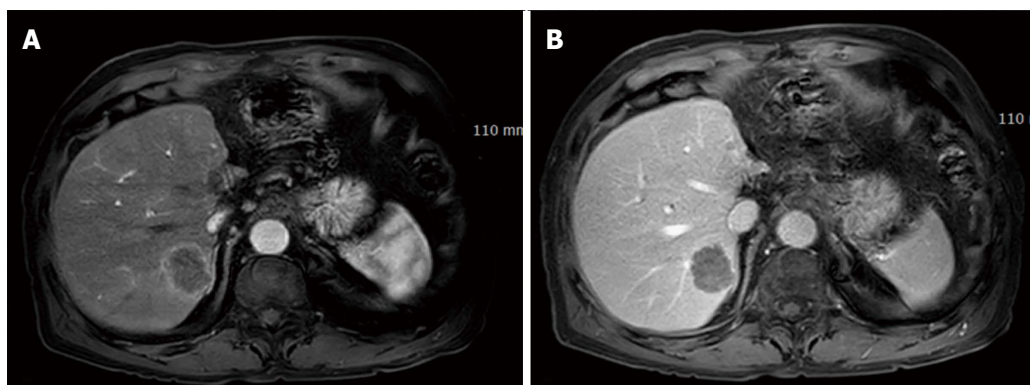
Magnetic resonance imaging of the liver after 6 mo. Five nodules were detected in the right lobe. The biggest was 3.3 cm. The nodules showed rim enhancement on the arterial phase (A) and low density on the portal phase (B).
